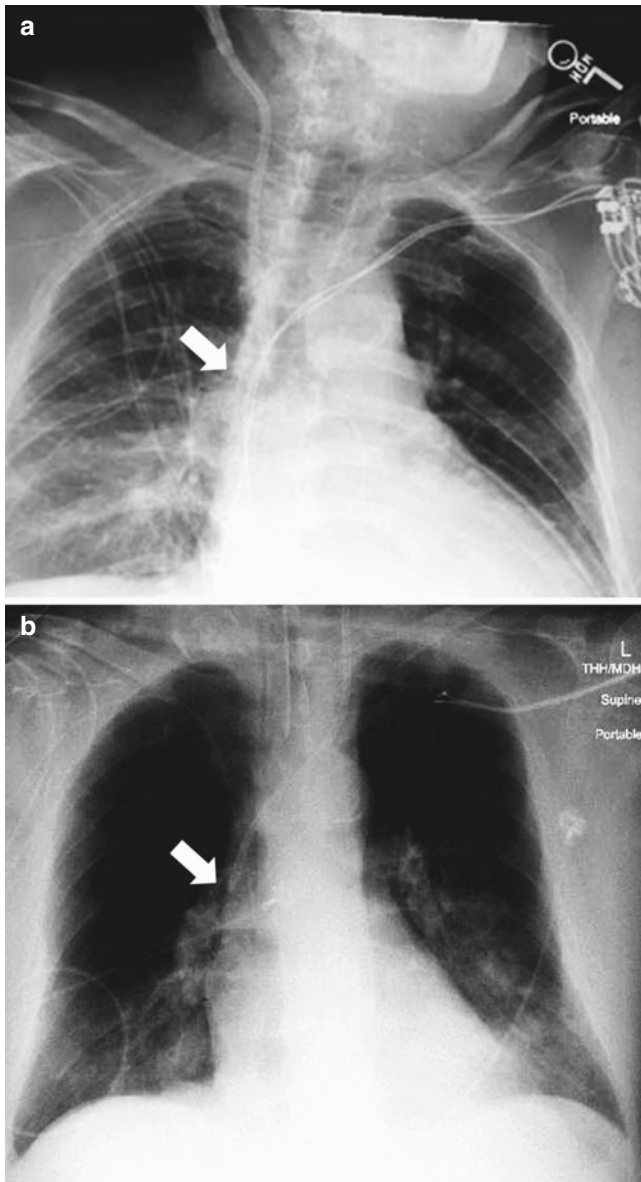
Post procedure chest x-ray demonstrating placement of non-tunneled hemodialysis catheter in critically ill patients terminating in the central SVC (arrows). (a) Right internal jugular catheter (b) left internal jugular catheter
